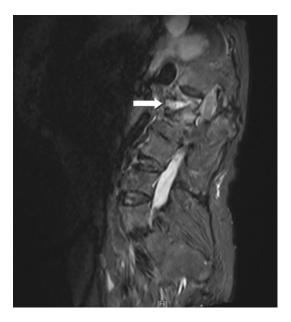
Preoperative magnetic resonance imaging demonstrating the 'vacuum cleft' which presenting high signal on the T2-weighted images. (The arrow mark location is the high signal area).
